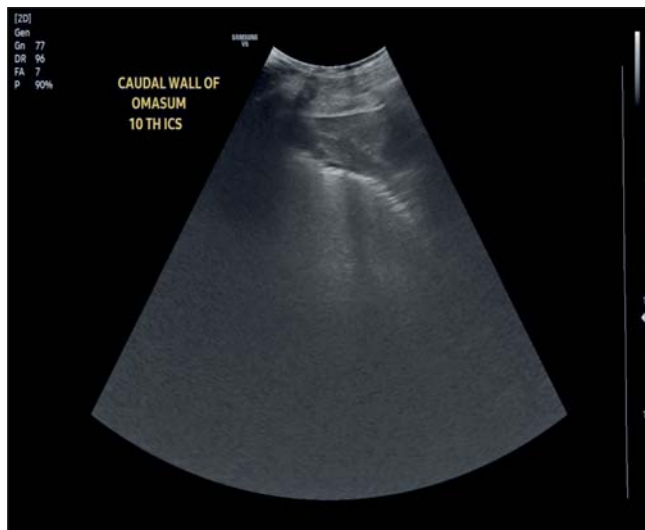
Ultrasonogram showing the Caudal wall of omasum at 10th ICS.
